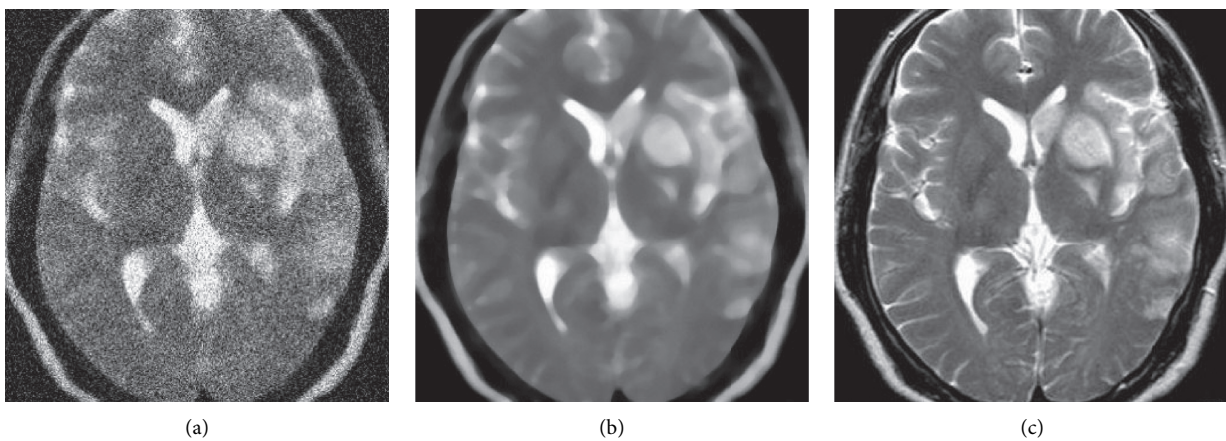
Visual comparison of head MRI images optimized and processed in different ways. (a) original head MRI image; (b) routine optimization of head MRI image; (c) BPF algorithm optimization of head MRI image.
